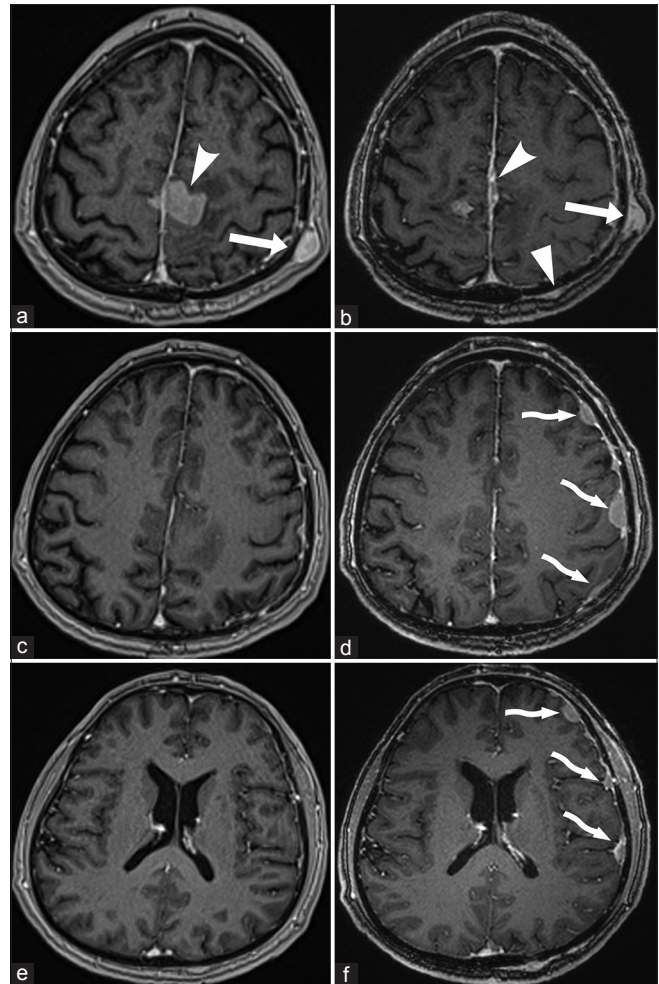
Compared to preoperative ones (left column, a, c, and e), T1-weighted magnetic resonance imaging with intravenously administered contrast at 4-month follow-up (right column, b, d, and f) revealed local recurrence of both the intracranial (curved arrowhead) and extracranial (arrow) masses along with the occurrence of additional intracranial masses located over the left cerebral hemisphere (curved arrow), while a new extracranial mass was also visible (arrowhead)
